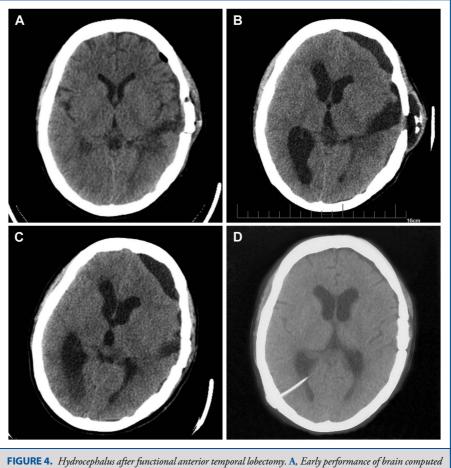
Hydrocephalus after functional anterior temporal lobectomy. A, Early performance of brain computed tomographyat 4 days after surgery. B and C, Hydrocephalus at 1 and 2 months after surgery. D, Remission of hydrocephalus at 1 month after shunt.
